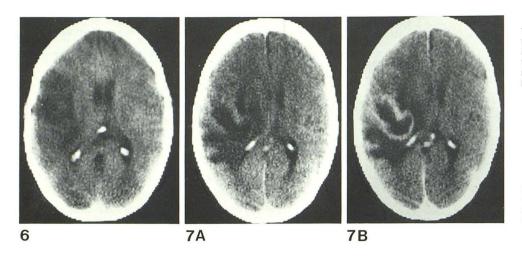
Enhanced CT scan of patient with large low grade astrocytoma of temporal lobe. Extensive area of hypodensity but no enhancement because new tumor capillaries resemble normal cerebral capillaries with maintenance of BBB.
